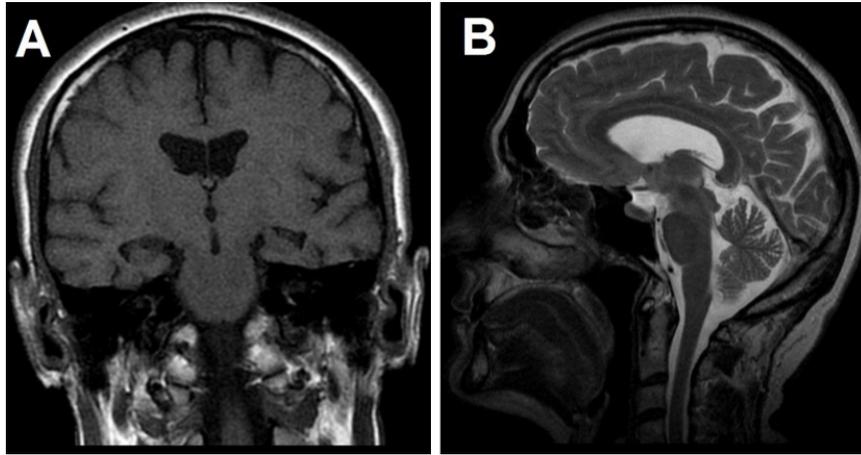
Brain magnetic resonance imaging of case 4. Coronal T1 section (A) reveals hippocampal atrophy. In sagittal T2 section (B), some degree of posterior frontal and parietal atrophy is observed
